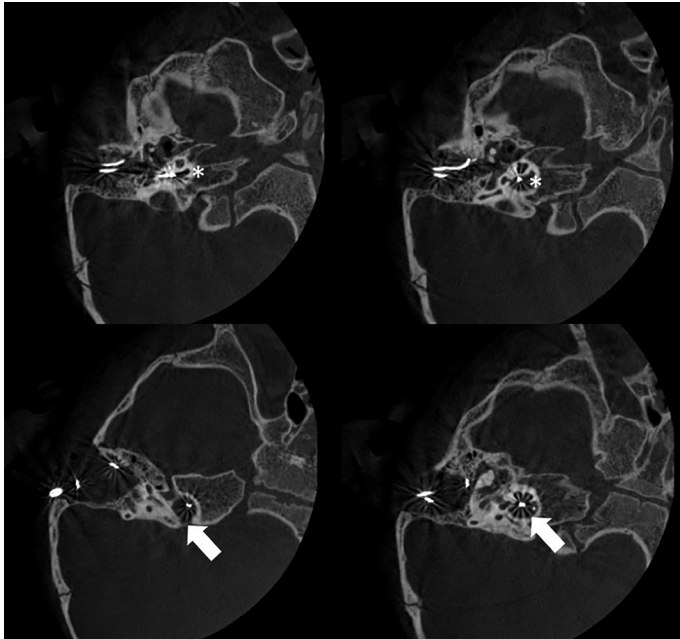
Axial view CT: cochlear implant electrodes reach the internal acoustic canal (white arrow) from the base of the cochlea (asterix).
